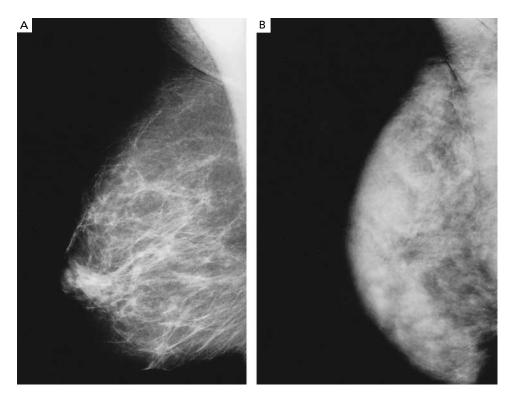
Mammograms Showing a Normal Breast in One Woman (Panel A) and a Breast with Extensive Areas of Radiographically Dense Tissue in Another Woman (Panel B). Figure provided courtesy of Dr. K. Bukhanov.
